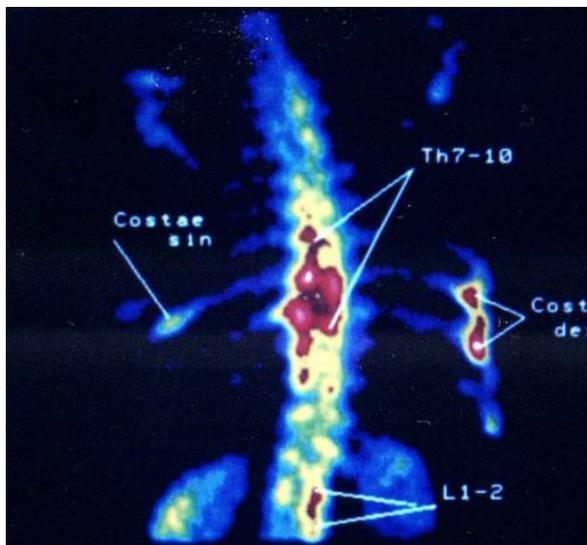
Radionuclide bone imaging (osteoscintigraphy), with ^{99m}Tc -phosphonates. Hyperfixing in chest and lumbar departments of the backbone; in ribs from both parties. Signs of metastases of a malignant tumour in a bone.
